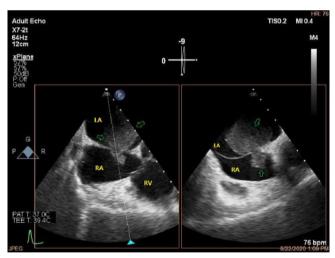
Transesophageal echocardiography shows a mass (arrows) in the LA and the RA.
